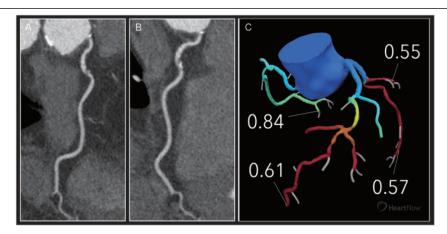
Ostial and proximal RCA stenoses (A and B) with negative computed tomography-derived fractional flow reserve (0.84) (C). All surgeons planned coronary artery bypass grafting (CABG) based on coronary computed tomography angiography but 4 surgeons changed their treatment strategy based on the computed tomography-derived fractional flow reserve result in the RCA resulting in a planned revascularization of only LAD and circumflex artery. During CABG, the patient received a left internal mammary artery on the distal LAD and a venous graft on segment 12a. LAD: left anterior descending artery; RCA: right coronary artery.
